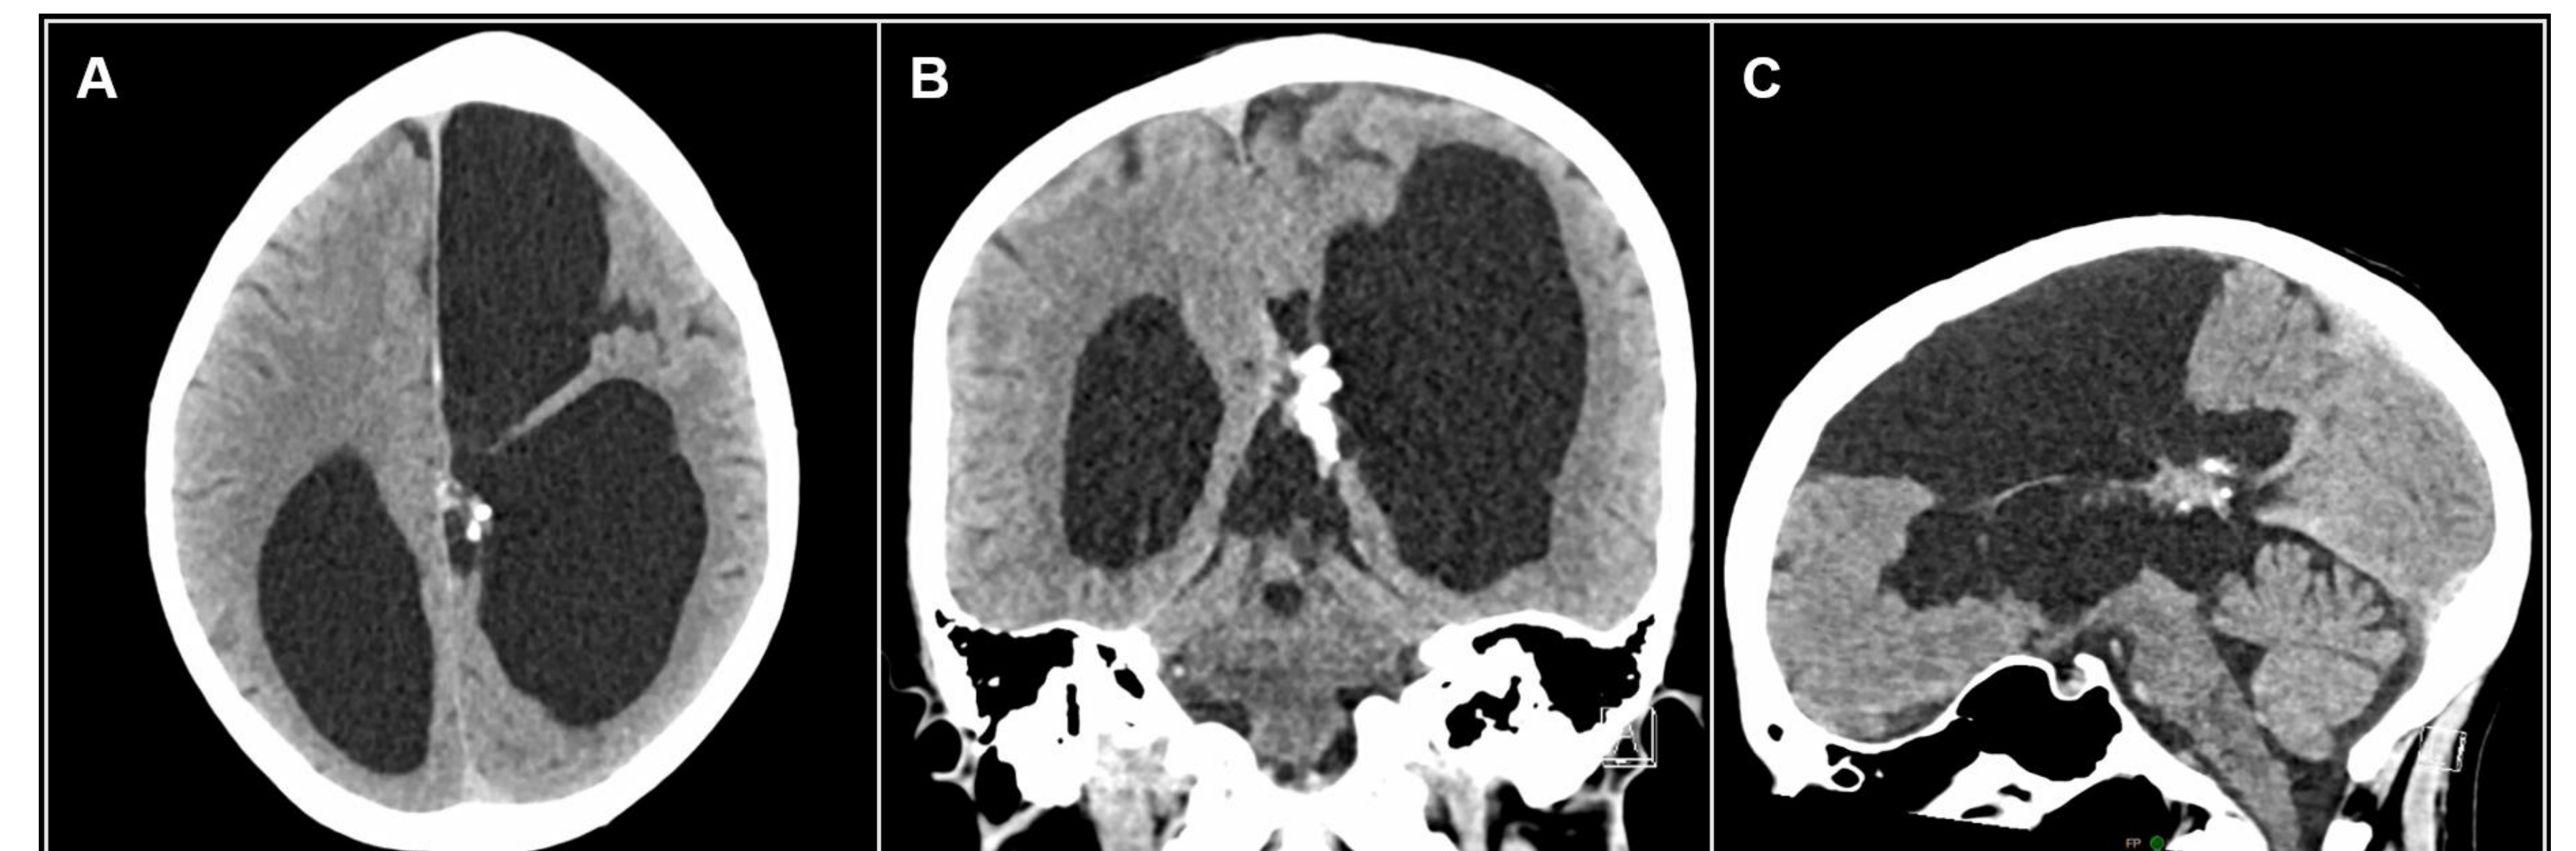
CT head with Axial (A), Coronal (B), and Sagittal (C) slices. There is profound agenesis of the corpus callosum and bilateral cystic encephalomalacia, including a large left hemispheric cavity (148x47x90 mm) consistent with severe schizencephalic porencephaly, extending from the anterior frontal lobe to the occipital lobe.
